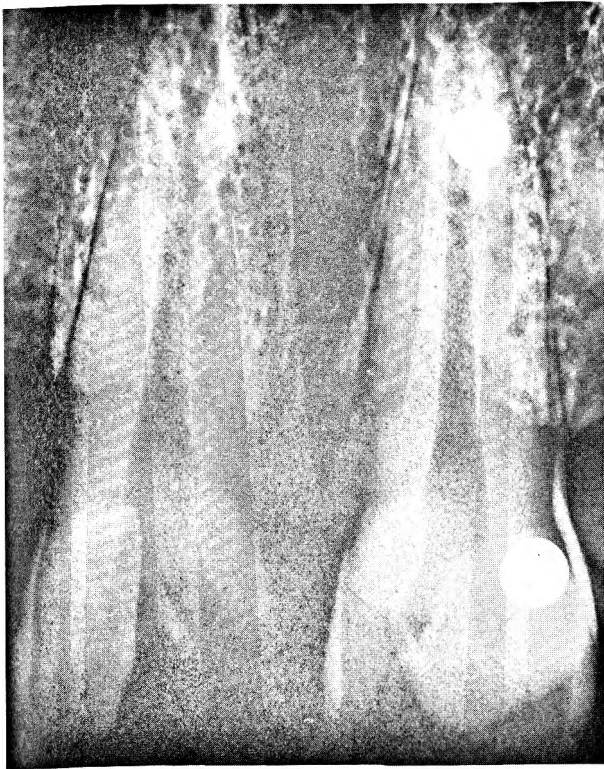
A radiographic film with the two 2 mm steel spheres. The coronal sphere is on the tooth, while the apical one, is on the film.
